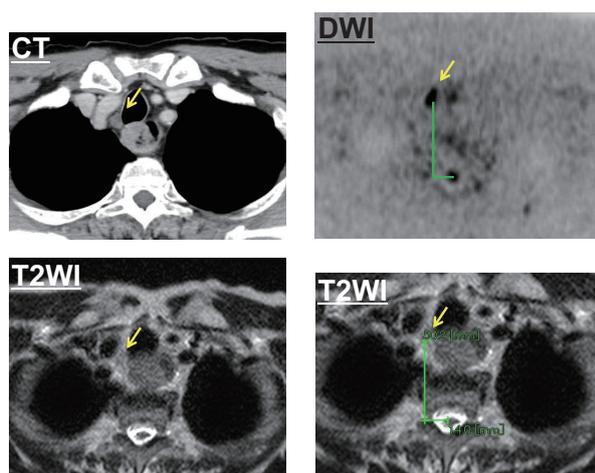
The site was identified using thin-slice CT, and spots that appeared to be lymph nodes at the same site were confirmed on MRI T2WI. A high signal was confirmed on DWI performed at the same level, and the ADC value was measured using the ADC MAP
